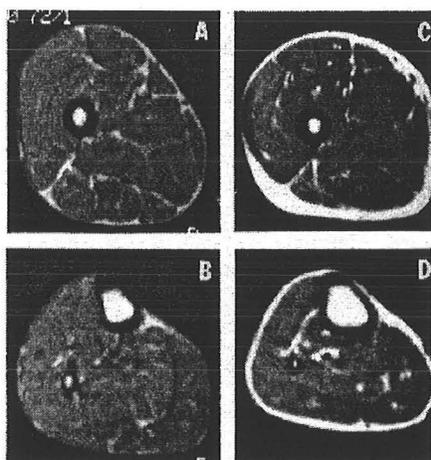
Axial MRI at the level of thigh (A) and calf (B) in an affected woman with FPLD showing near complete absence of subcutaneous fat but preservation of intermuscular and bone marrow adipose tissue (increased signal intensity [brightness]). Scant sc adipose tissue can be seen in the medial and posterior aspects of the thigh. Similar images at the level of thigh (C) and calf (D) from a healthy female show normal amount of sc, intermuscular and bone marrow fat.
